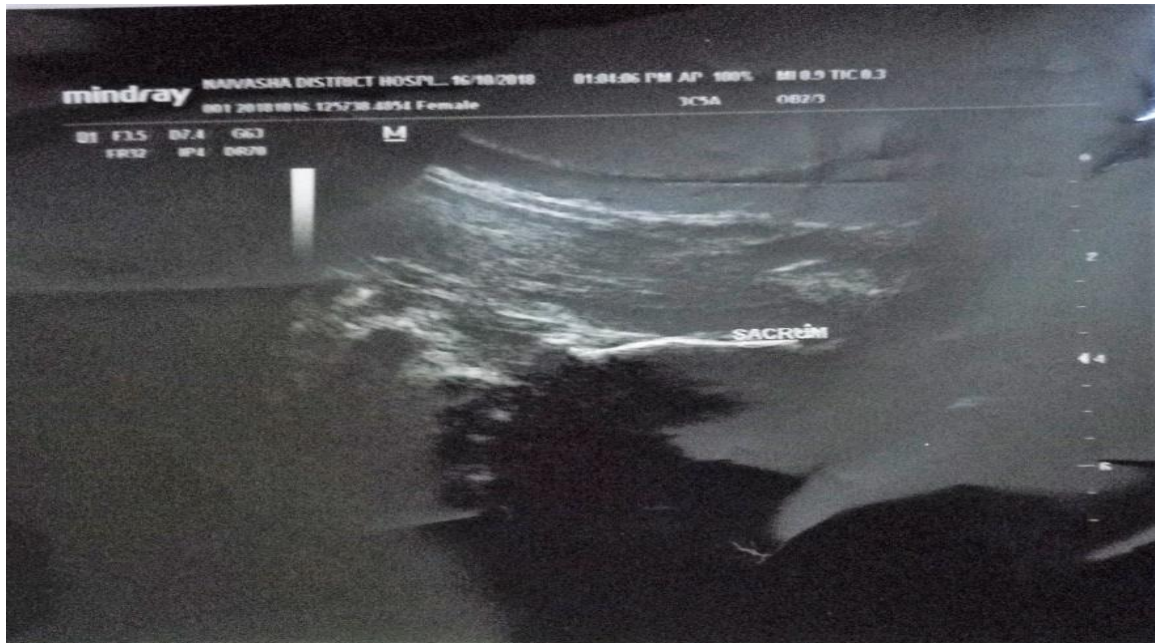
Paramedian sagittal ultrasound image of the sacrum.
